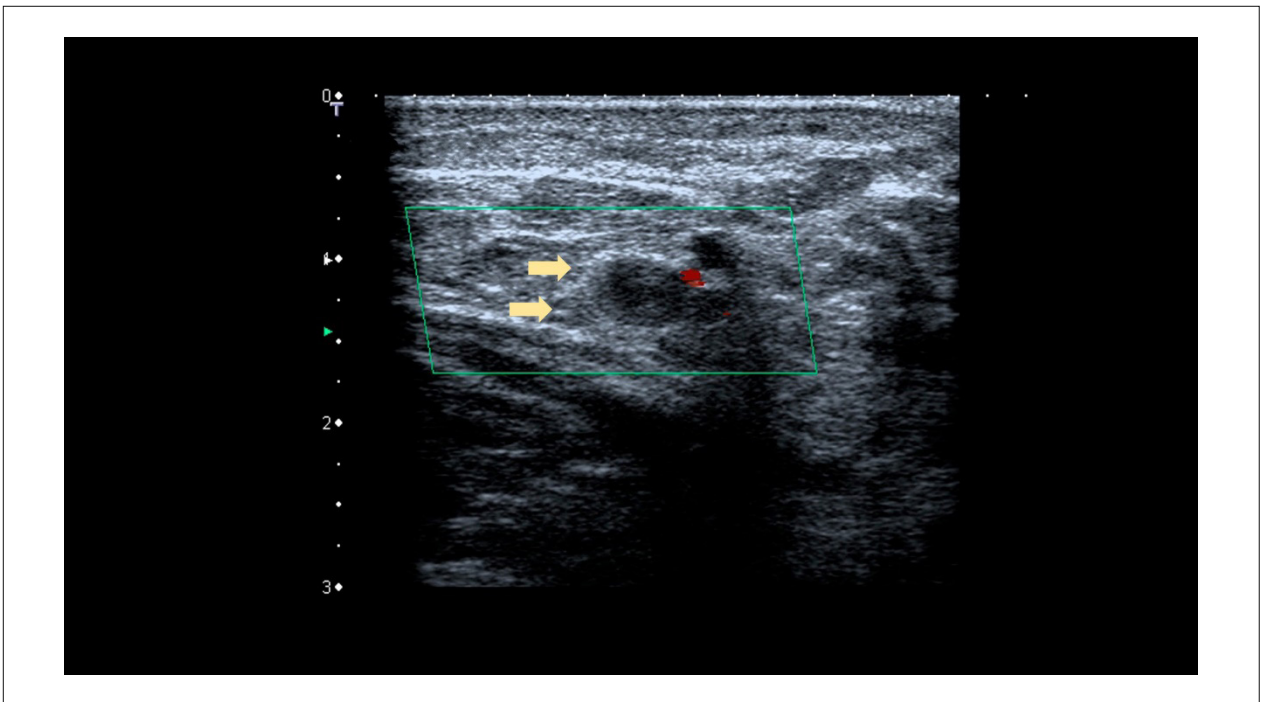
Color flow Doppler image showing venous thrombosis of noncompressible plantar veins without flow.
